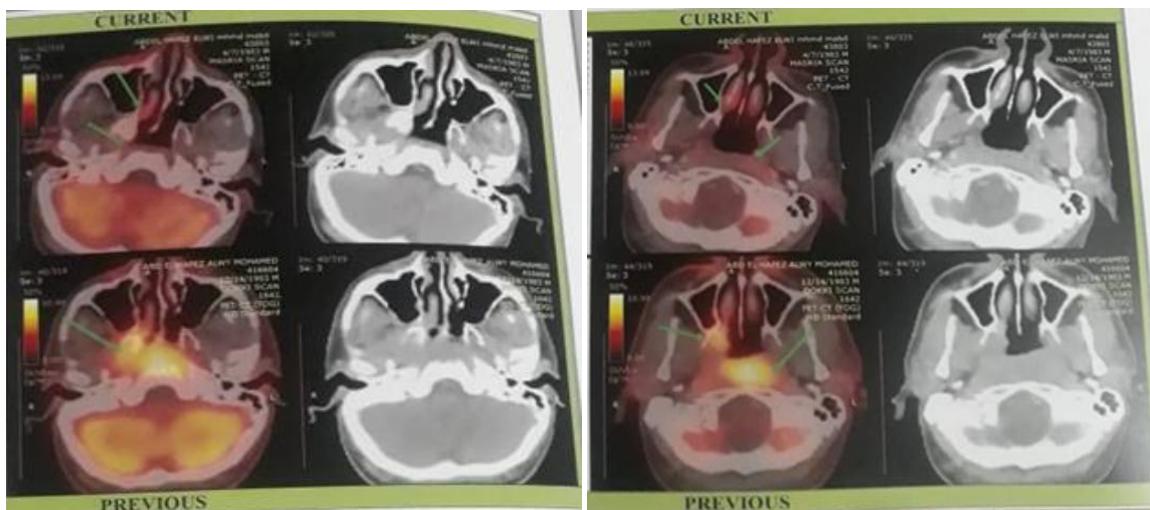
CT scan case 2.
